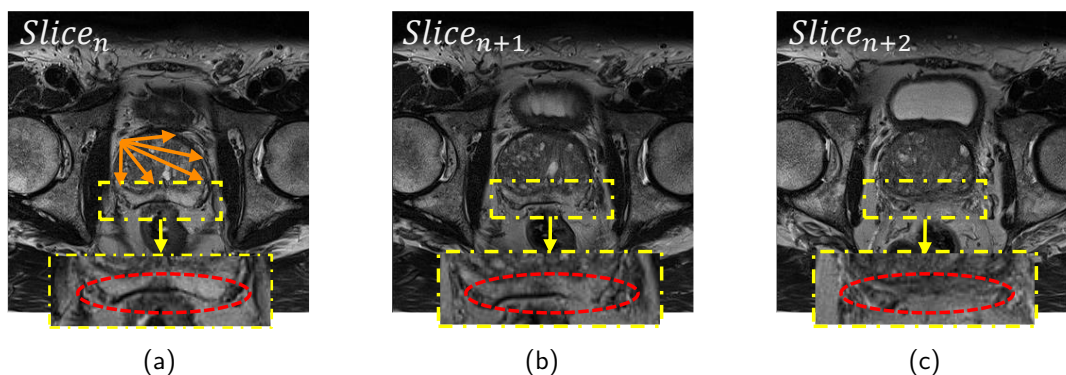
Intra-slice and inter-slice dependencies in prostate MR images. Intra-slice dependencies are pixel relationships in one MR image slice (like the orange arrow in (a)), and inter-slice dependencies are pixel relationships among continuous MR slices (like the red ellipses in (b) and (c)), both of which could contribute to prostate boundary prediction in some low-contrast regions or obscure organ boundaries.
